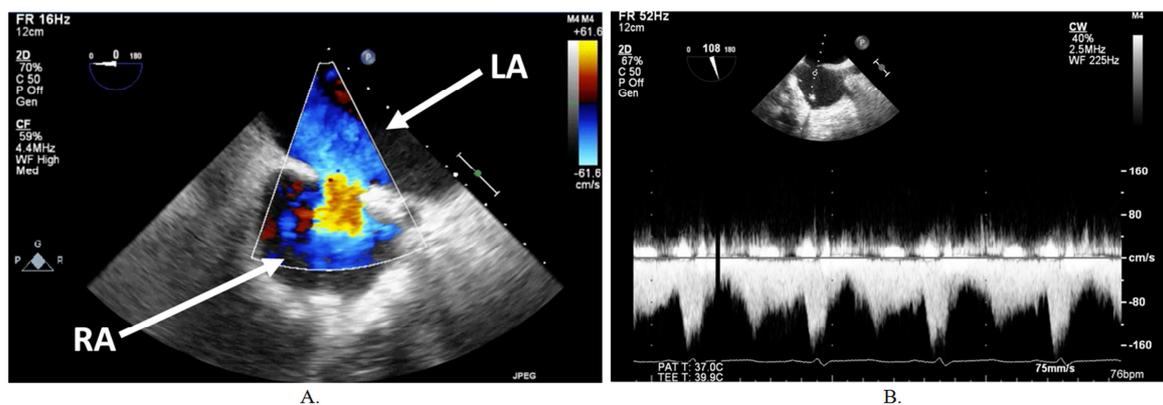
Transesophageal Echocardiography Images Obtained After Induction.
